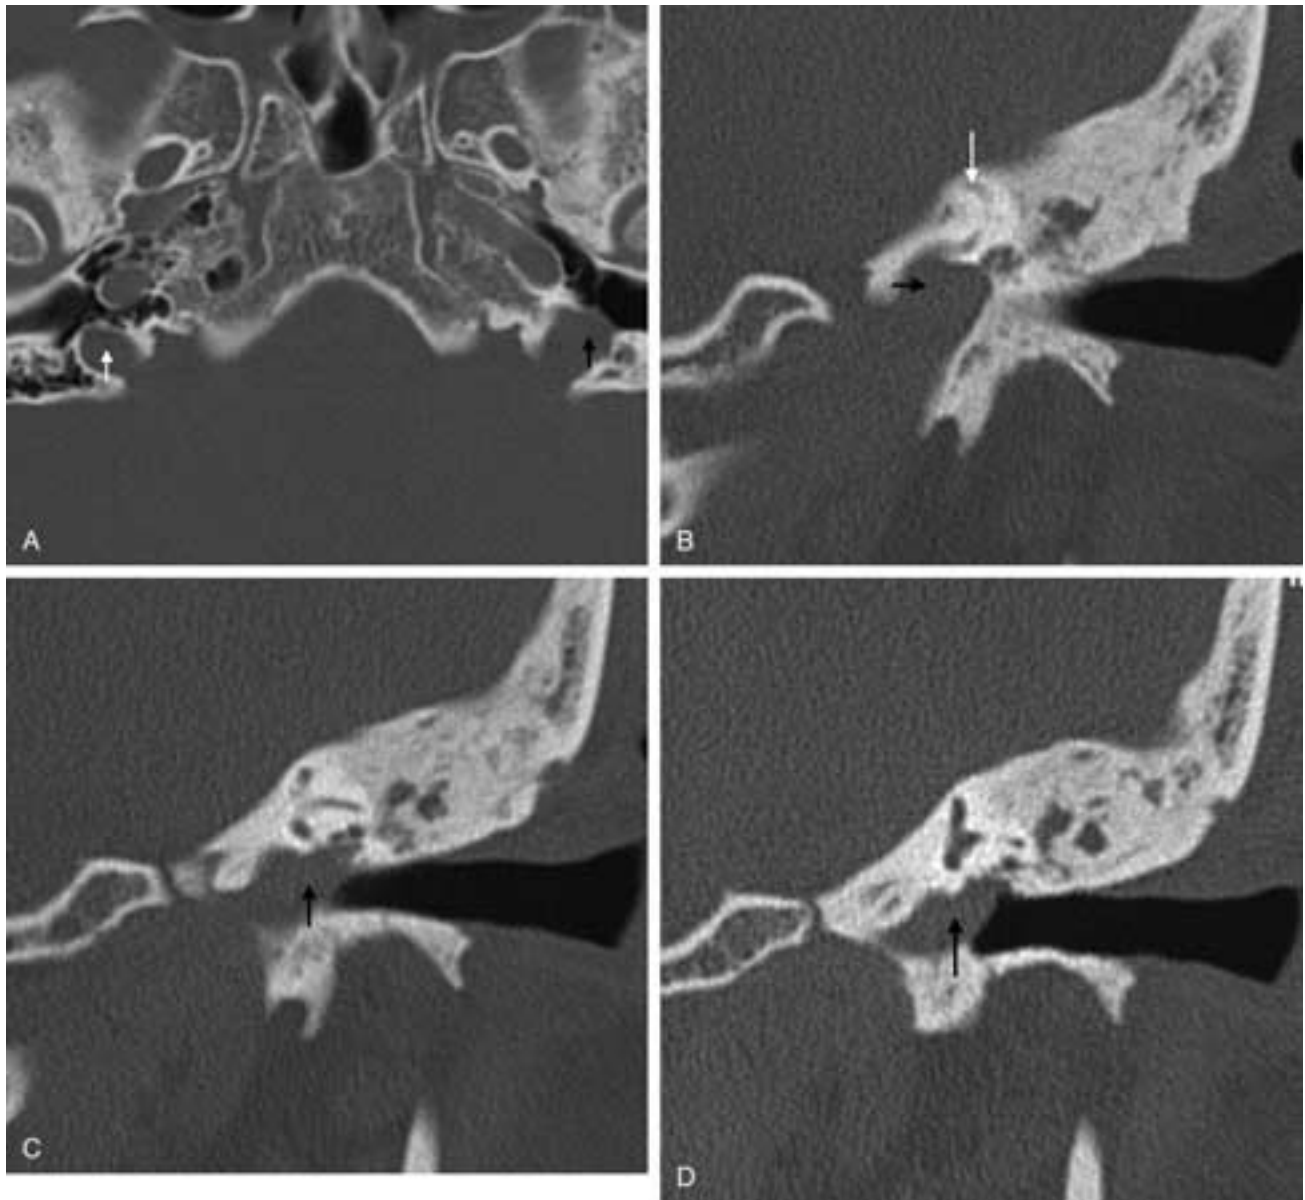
High-riding jugular bulb. A, Axial CT image showing a normal right jugular bulb (*white arrow*) and a high-riding left jugular bulb (*black arrow*) projecting into the left hypotympanum. B to D, Three contiguous coronal CT images, from posterior to anterior, showing a high-riding left jugular bulb (*black arrow*) abutting the PSCC (*white arrow* in B) and extending into the middle ear cavity in C and D.
